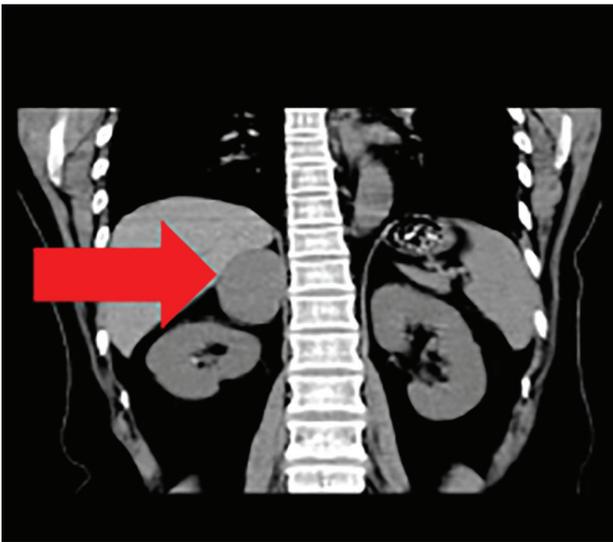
Coronal adrenal CT scan. The coronal CT scan of the adrenal gland revealed a tumor (45x40 mm; arrow) on the right adrenal gland. The presence of pheochromocytoma or lymphoma was considered. CT, computed tomography.
